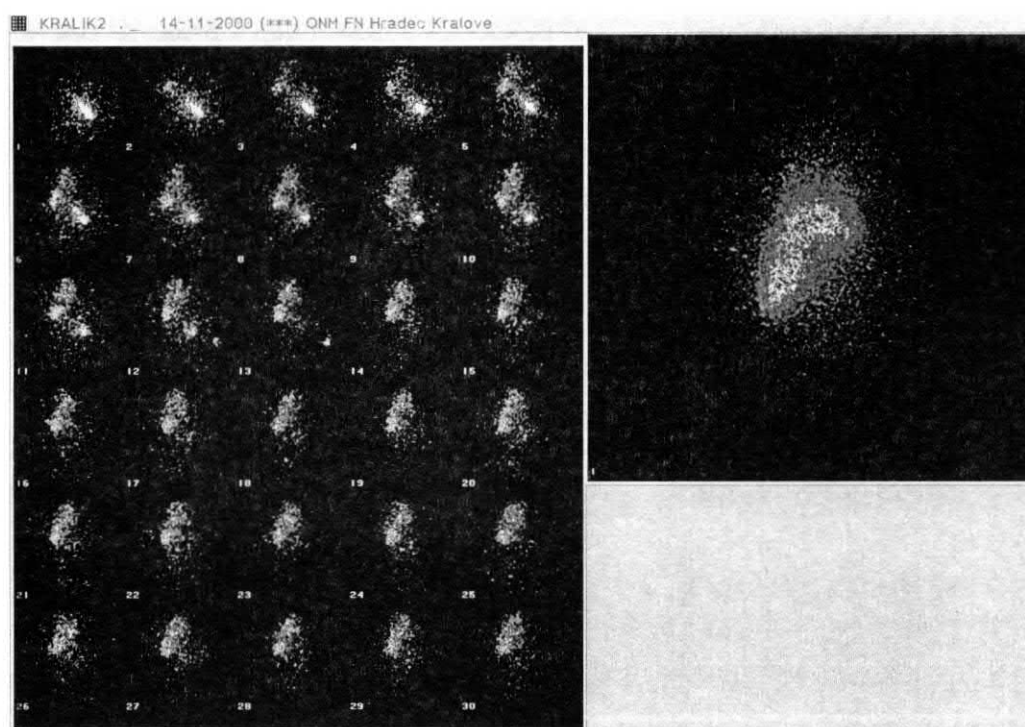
^{131}I -lipiodol administered into the portal vein (dynamic scintigraphy 0–5 min. pictures no. 1–30, static mode 5.–12. min - see right big picture)
